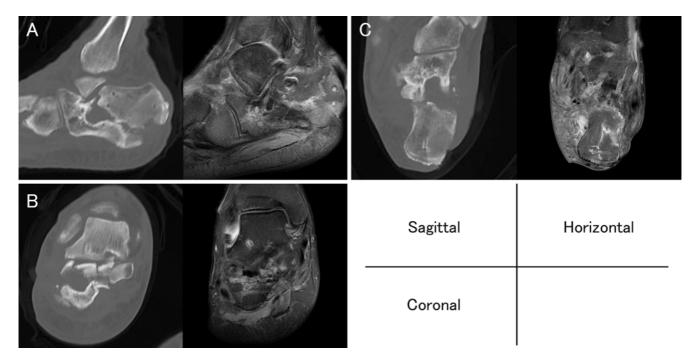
Preoperative CT (left) and contrast-enhanced T2-weighted MRI findings (right) of the calcaneum. (A) Sagittal section; (B) horizontal section; and (C) coronal section.
